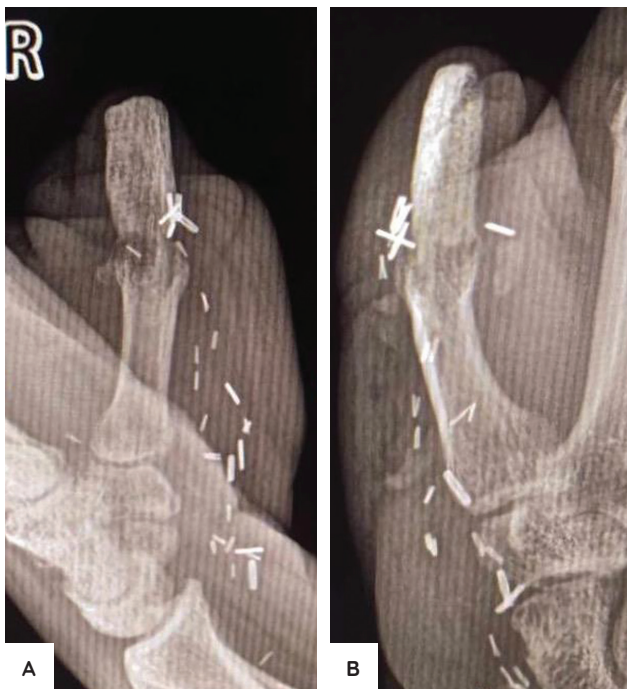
Radiographic evaluation at 2 months postoperatively. Lateral view (A) and anteroposterior (AP) view (B) of the right thumb demonstrate stable fixation and radiographic evidence of graft incorporation without signs of loosening, fracture, or infection.
